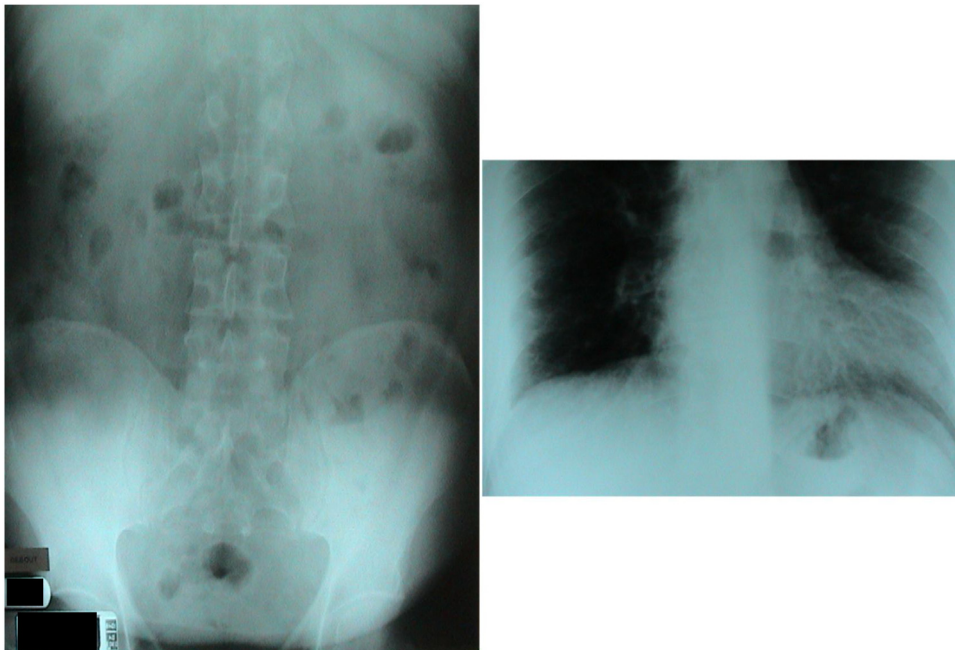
Abdominal X-ray: No intestinal distension, no air-fluid level, and no pneumoperitoneum.
